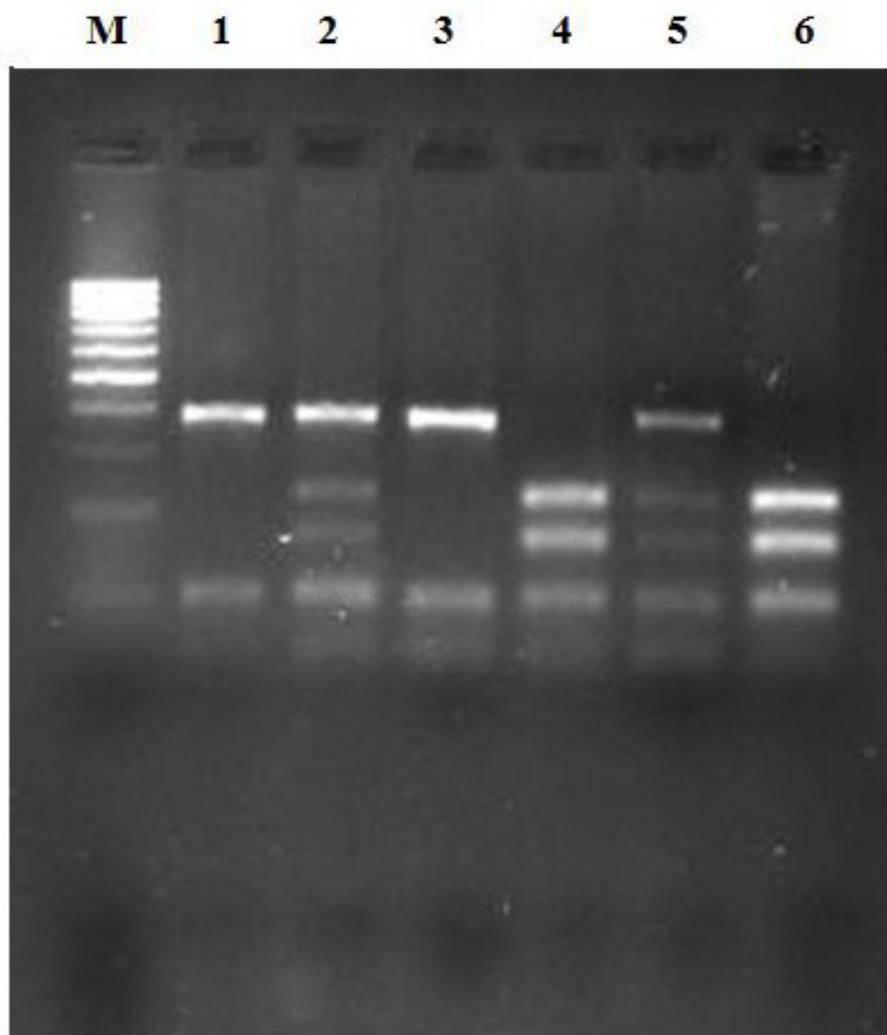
Representative gel of *MTHFR* C677T polymorphism, representing amplicon digest with *Hinf*I (G|ANTC/CTNA|G); where the variant TT is cleaved but not the wild-type CC. Lane M = 100-bp ladder. Lanes 1 and 3 = wild-type (CC) form (394 and 100 bp). Lanes 2 and 5 = heterozygous (CT) variant form (394, 229, 165, and 100 bp). Lanes 4 and 6 = homozygous (TT) variant form (229, 165 and 100 bp).
